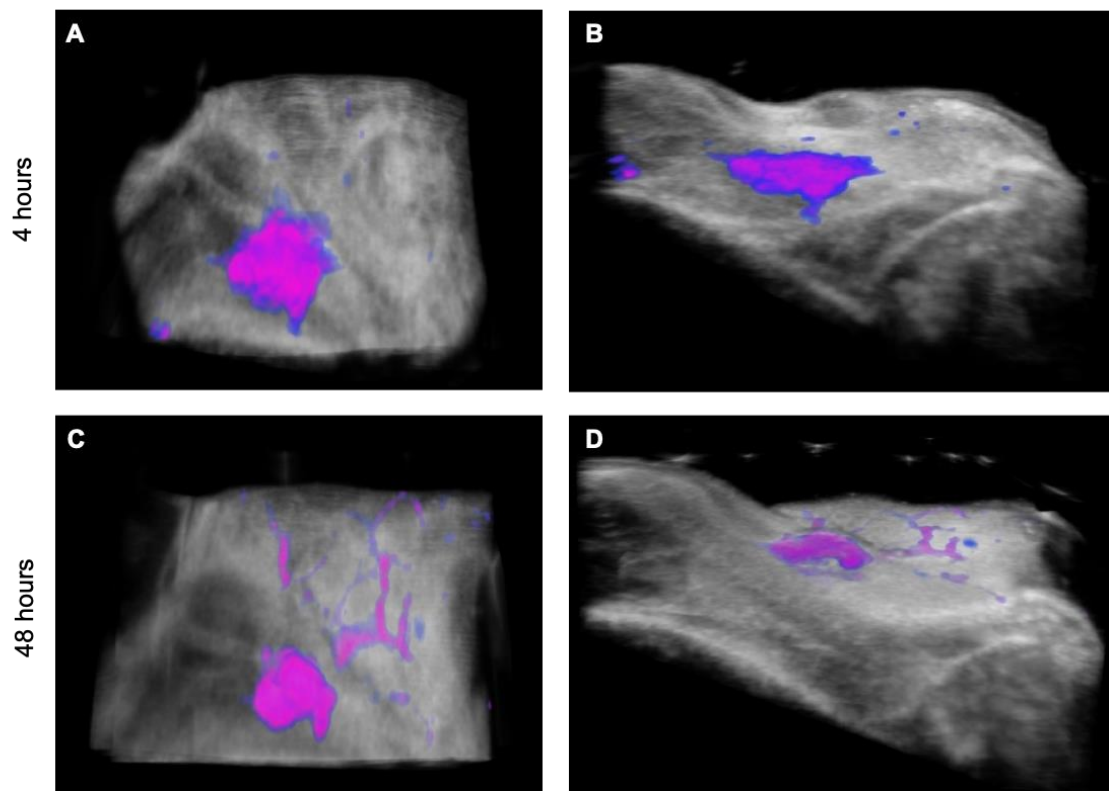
Three-dimensional volumetric images of CpG-Dye950-nPLP trafficking from the injection site. Ultrasound (grayscale) depicts anatomy and spectroscopic PA analysis (color scale) distinguished CpG-Dye950-nPLPs at 4 hours (A, B) and 48 hours (C, D) post-injection. The size of the injection site decreased by 48 hours post-injection and PLPs appeared to be in superficial vessels (C, D).
